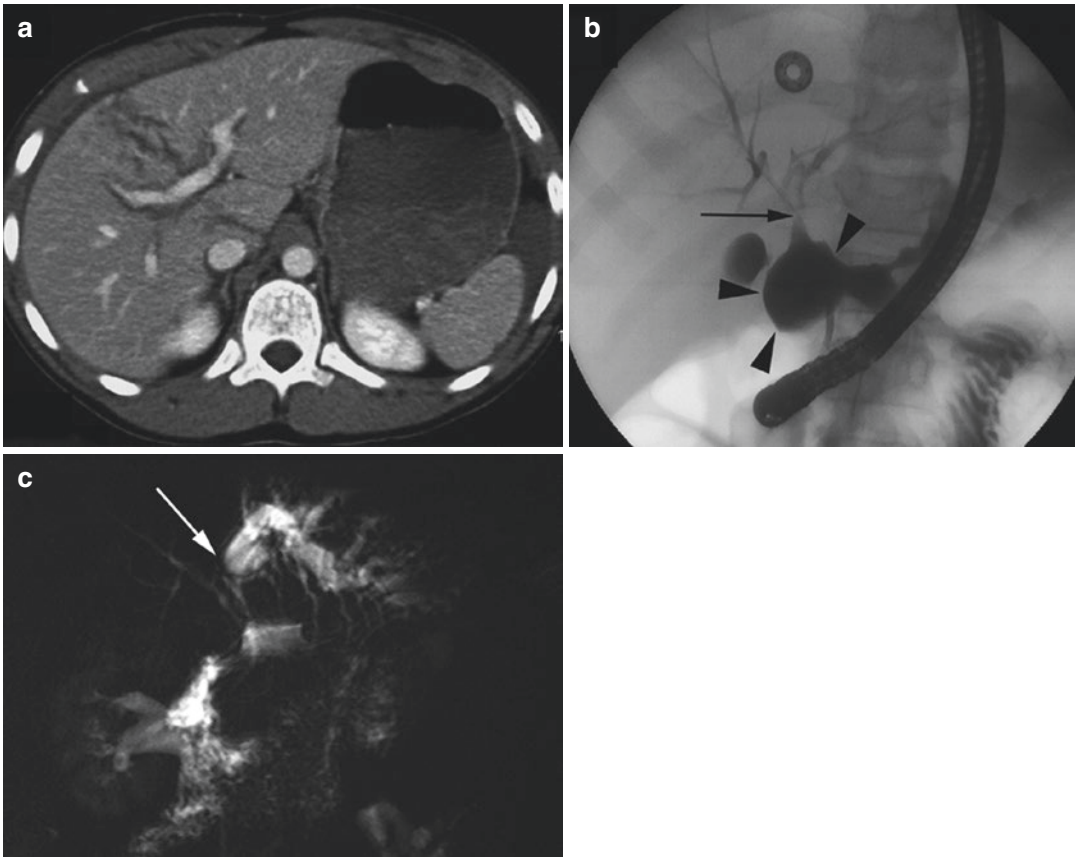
Thirteen year old boy, Auto crash. (a) Initial CT with contrast: liver fracture (grade III) against portal bifurcation. (b) Endoscopy: follow-up demonstrates fluid effusion (*black arrow heads*) in relation with biliary duct
